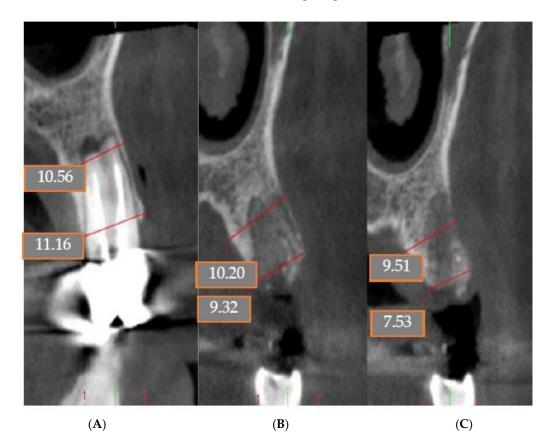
(A) Previous CBCT; (B) Immediate postoperative CBCT; (C) Postoperative CBCT after 4 months.
